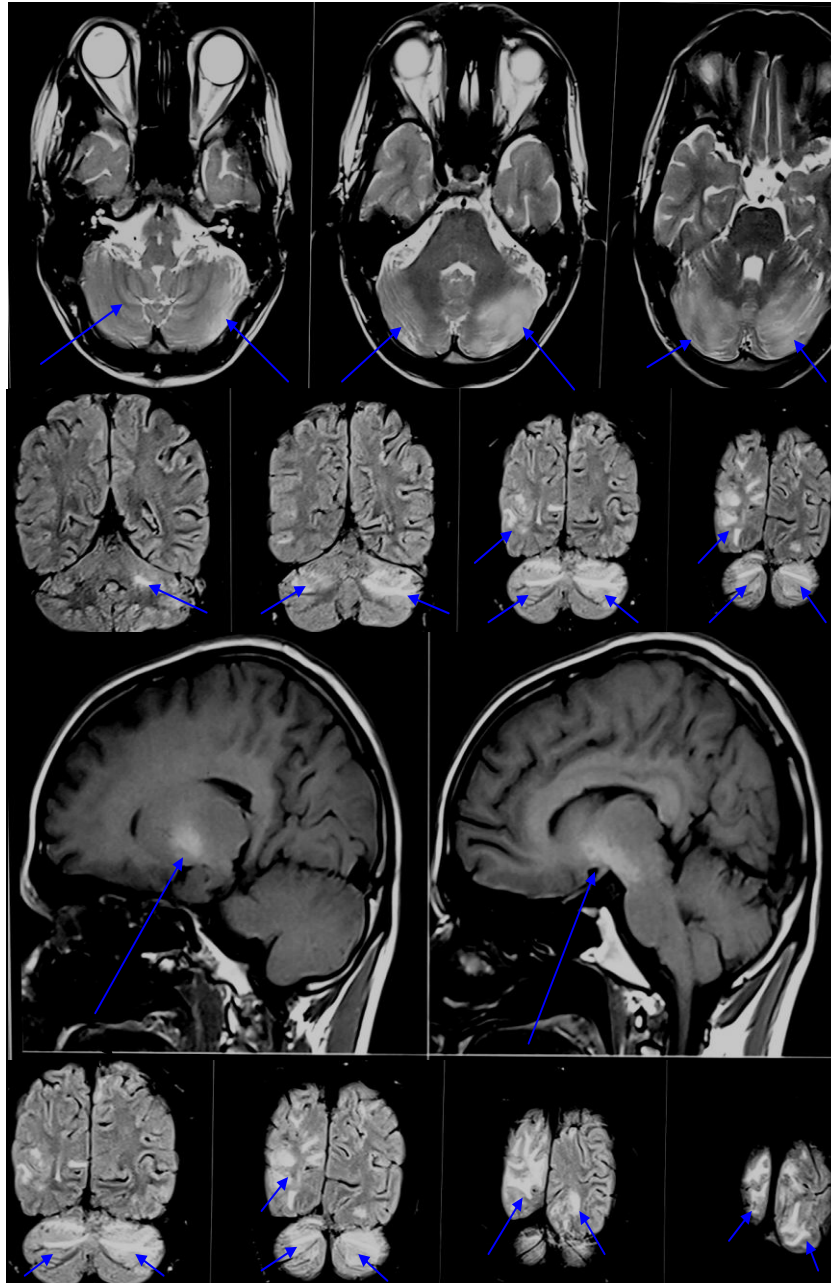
MRI Brain showed areas of altered signal intensity noted in bilateral occipital gyri and cerebellum which were hypointense on T1 and hyperintense on T2/FLAIR with no area of blooming on gradient recalled echo (GRE) features suggestive of PRES. Hyperintense lesions were noted in basal ganglia, cerebral peduncle bilaterally on T1 and hypointense on T2/FLAIR with no blooming on GRE suggestive of encephalopathy.
